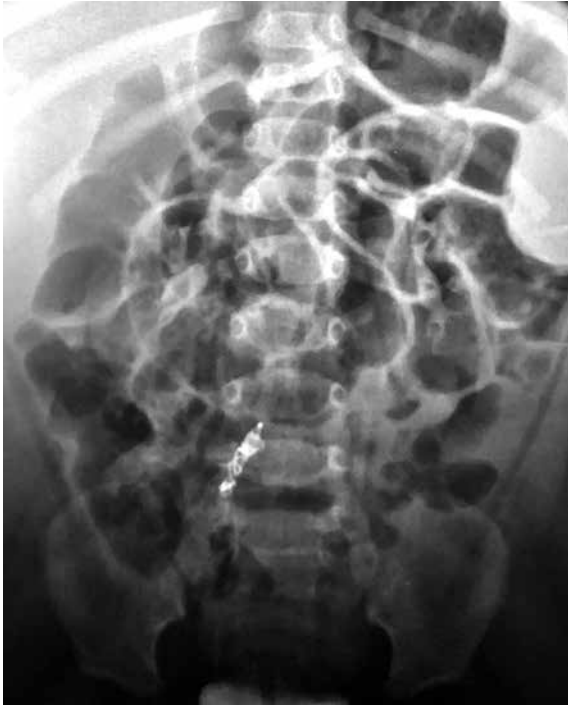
Posteroanterior abdominal X-ray showing embolized duct occluder device with the snare guidewire entwined and squeezed.
